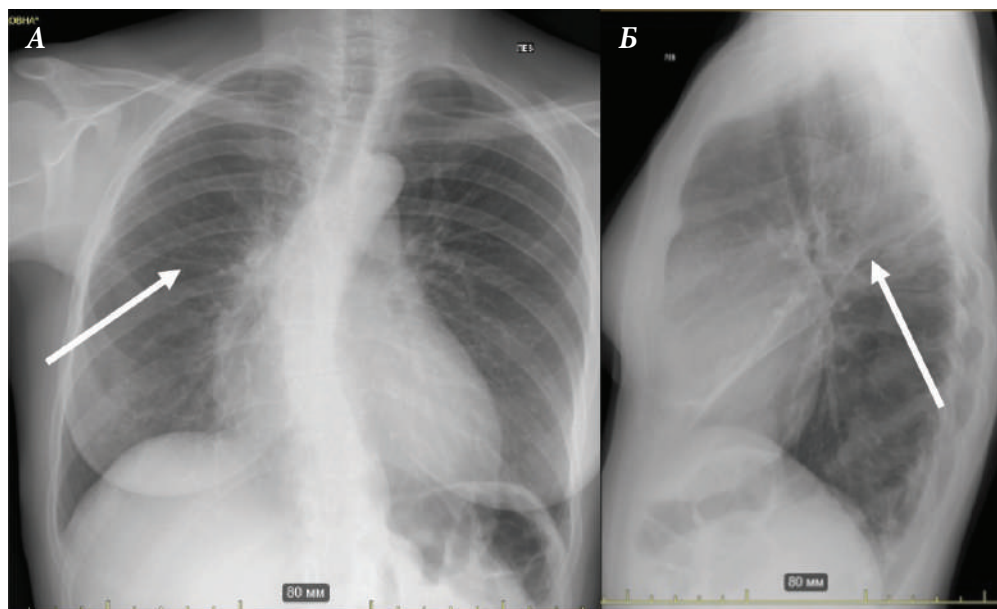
Radiography of chest organs in 2 projections dated 23.11.2019.
